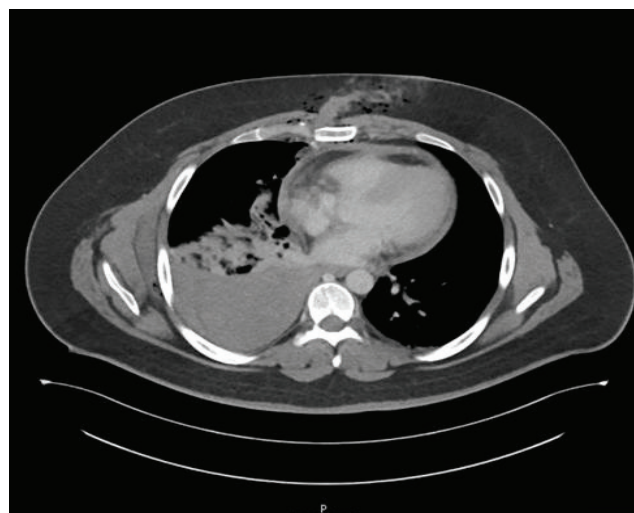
CT scan showing a small to moderate amount of pericardial effusion and pneumohemothoraxright
